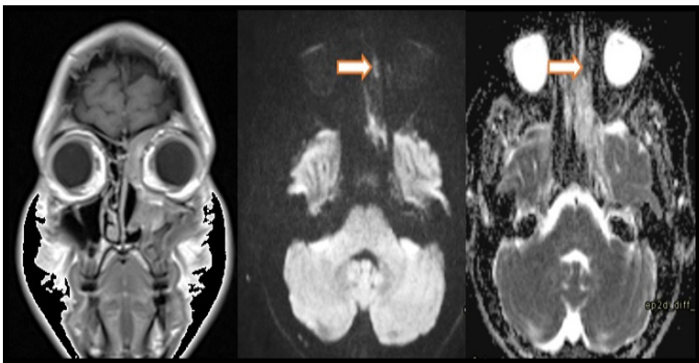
MRI TIWI Coronal, Axial DWI, and ADC Images – MRI Post surgery revealed diffuse mucosal thickening in the left maxillary sinus, left ethmoidal air cells and left frontal sinus seen on the TIWI coronal view and abnormal fluid restriction in the left ethmoid air cell on DWI with corresponding low signal on ADC.
